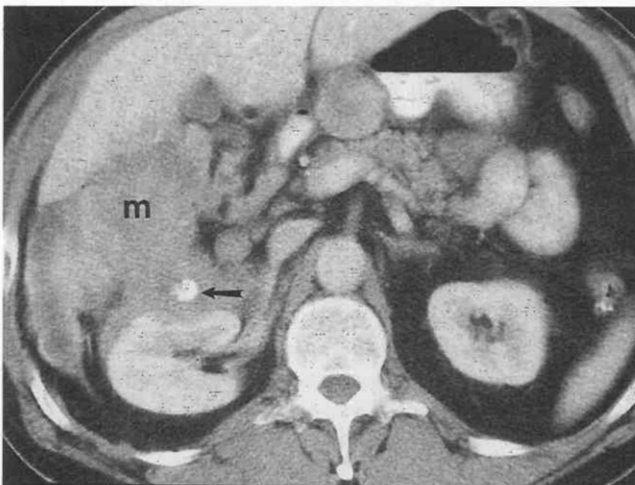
Malignant fibrous histiocytoma. Contrast-enhanced CT image obtained through the abdomen in a 61-year-old man shows a large heterogeneous mass (m) anterior to the right kidney and posterior to the liver. Although many primary retroperitoneal malignancies can appear heterogeneous, the presence of calcification (arrow) suggests the specific diagnosis of malignant fibrous histiocytoma.
